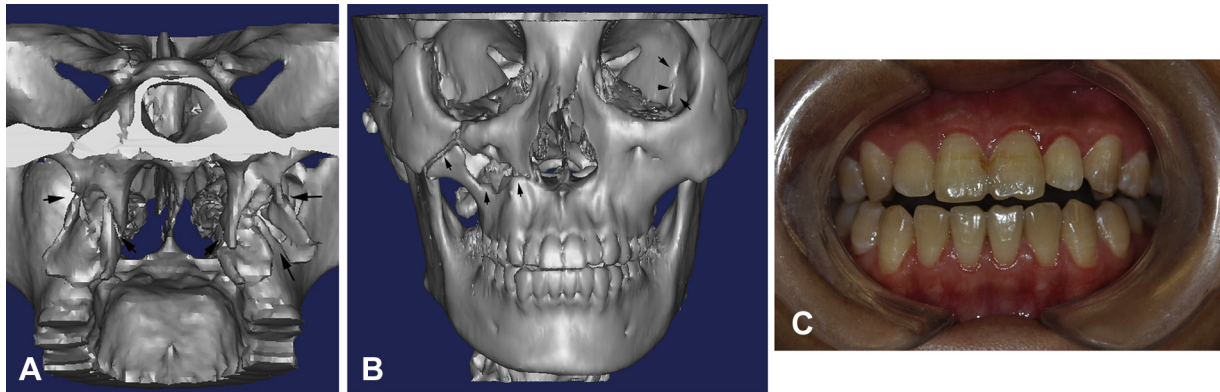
A young female patient with facial trauma. A, A preoperative 3-dimensional computed tomography image showed bilateral pterygoid process class II-II fractures associated with class I fractures. B, A 3-dimensional computed tomography image showed right-sided maxillary LeFort I and II fractures and left-sided maxillary LeFort III fractures. The left-sided maxillary fracture line was not clear, so the left-sided pterygoid process fracture can be used as indirect evidence for the left-sided maxillary fracture. C, A preoperative open bite deformity in the anterior teeth region suggested that bilateral maxillary transverse fracture existed.
